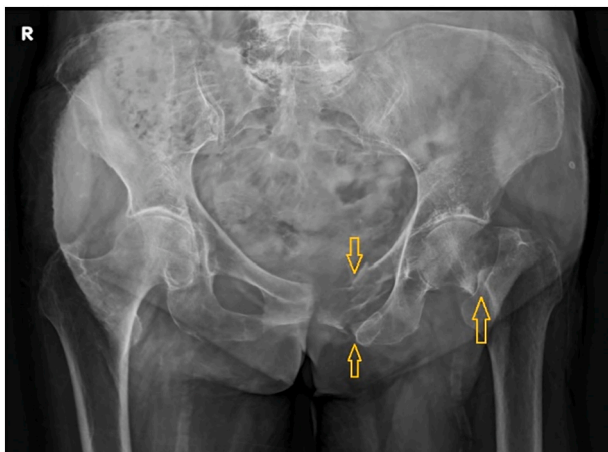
Antero-posterior radiograph of the pelvis showing a left displaced sub-capital femoral neck fracture along with displaced superior and inferior pubic rami fractures.
